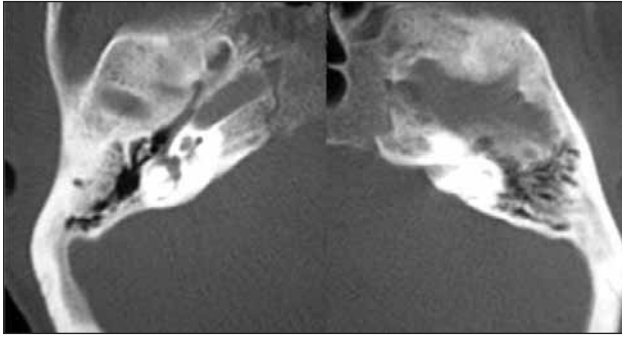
A high-resolution CT scan of the base of the skull demonstrates a normal bony carotid canal on the right side, and complete absence on the left.
